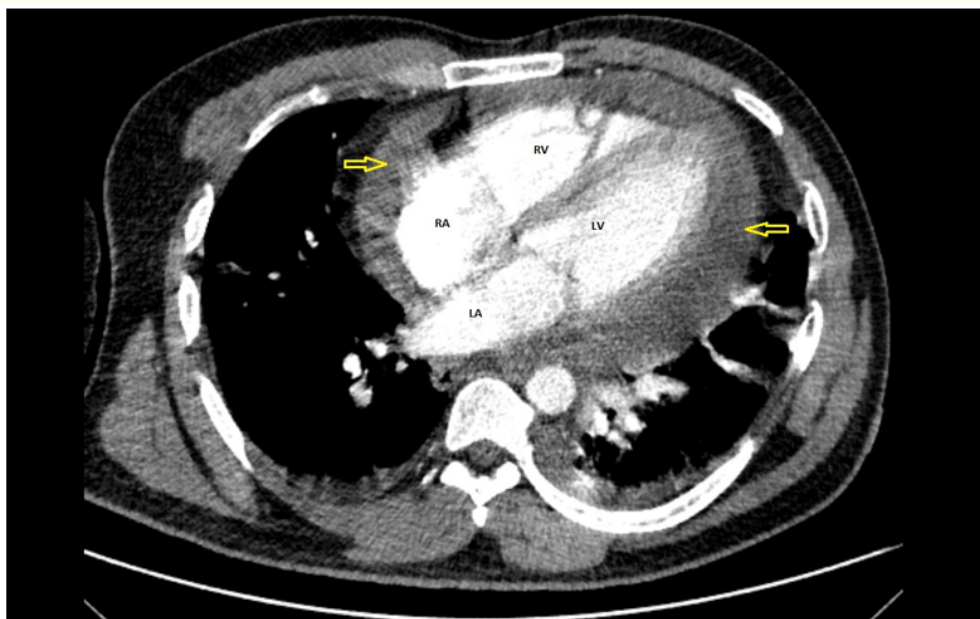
CT scan of thorax (with intravenous contrast) shows heart with labelled cardiac chambers and a large global pericardial effusion (arrows).
